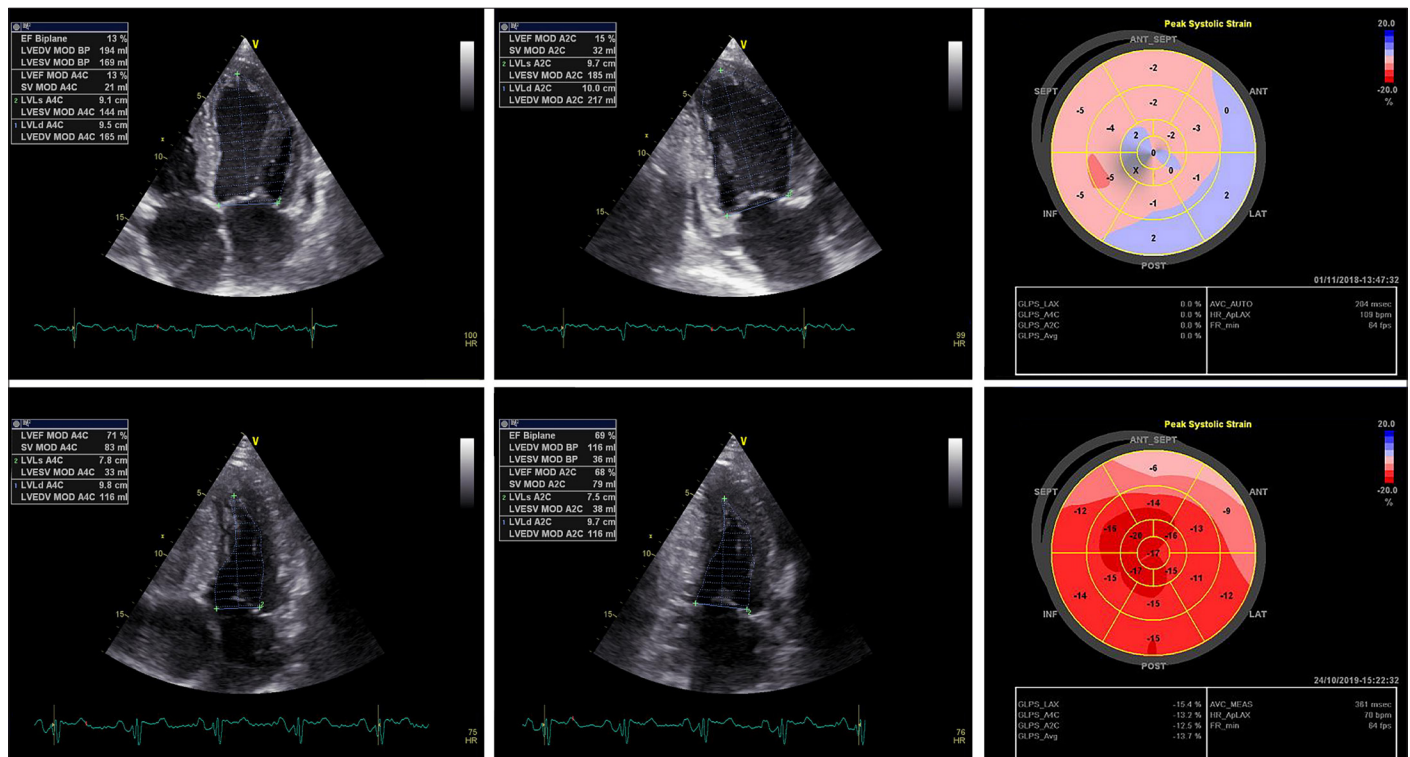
Pre- (upper panel) and post-transplant (lower panel) echocardiographic images from case #1 indicate a substantial improvement in left ventricular ejection fraction, left ventricular volumes, and global longitudinal strain. See Table 2 and Video 1
